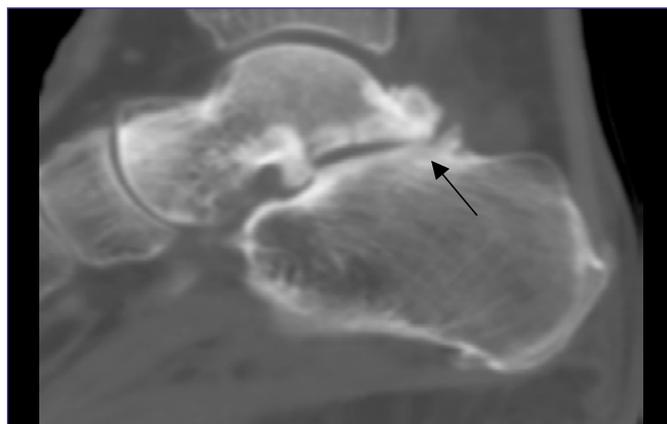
Clinically posterior impingement in a 37-year-old man. Sagittal CT reconstruction shows a prominent lateral posterior process of the talus (Stieda process) with secondary degenerative changes (arrow) between the posterior facet of the talus and the calcaneus consistent with a posterior impingement.
